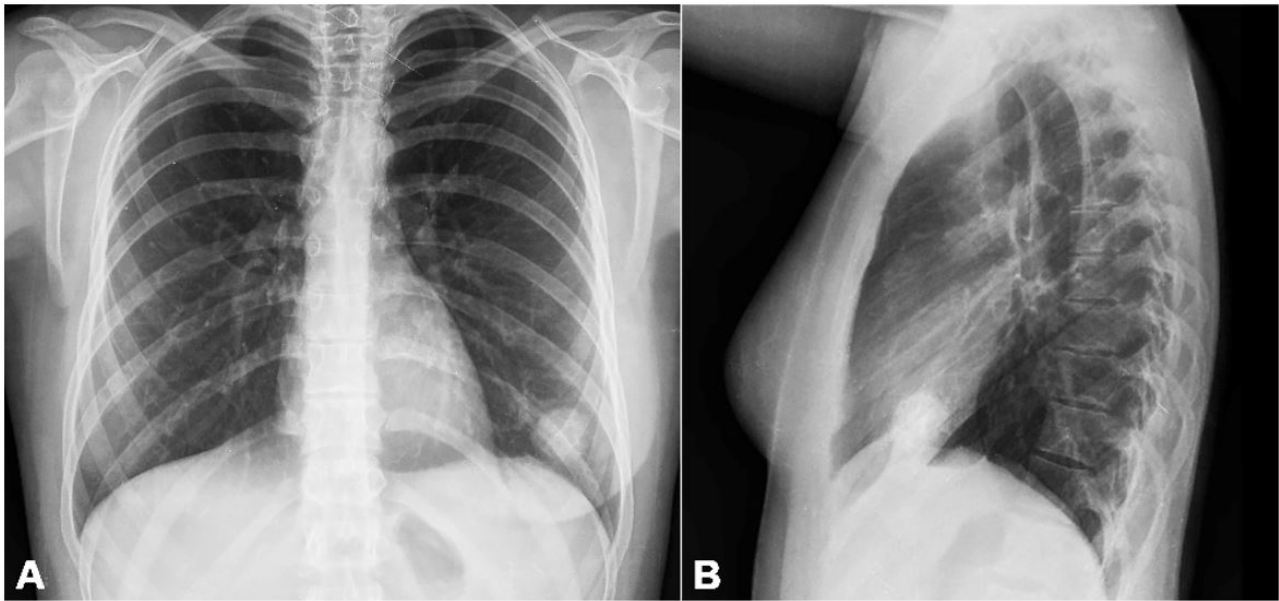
Chest x-ray showing in A and B a round (coin lesion) opacity in the left lower pulmonary lobe.
